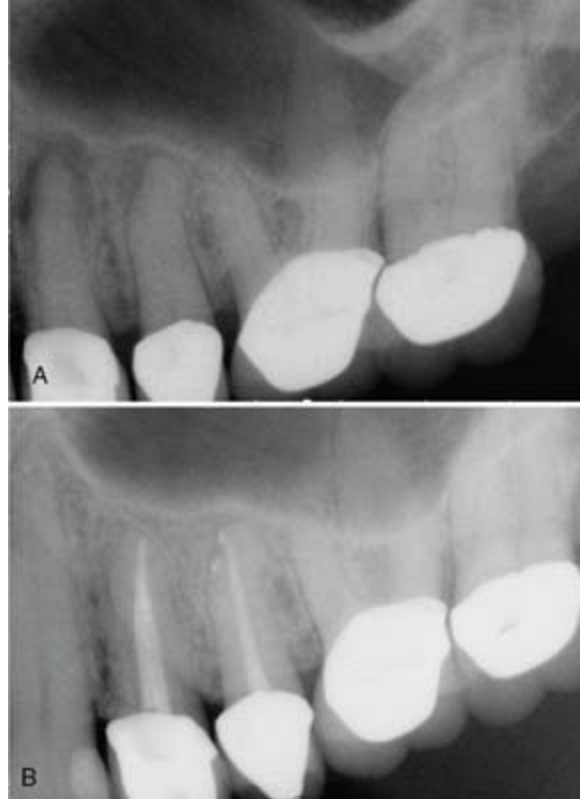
A, Multiple periapical radiolucencies suggest the possibility of a noninflammatory etiology. However, teeth #12 and #13 did not respond to cold testing and both teeth were tender to percussion and palpation. The diagnosis for tooth #12 and tooth #13 was pulp necrosis and symptomatic apical periodontitis. Nonsurgical root canal treatment was completed in both teeth. B, A 6-month recall demonstrated bone healing at the root ends of both teeth.
